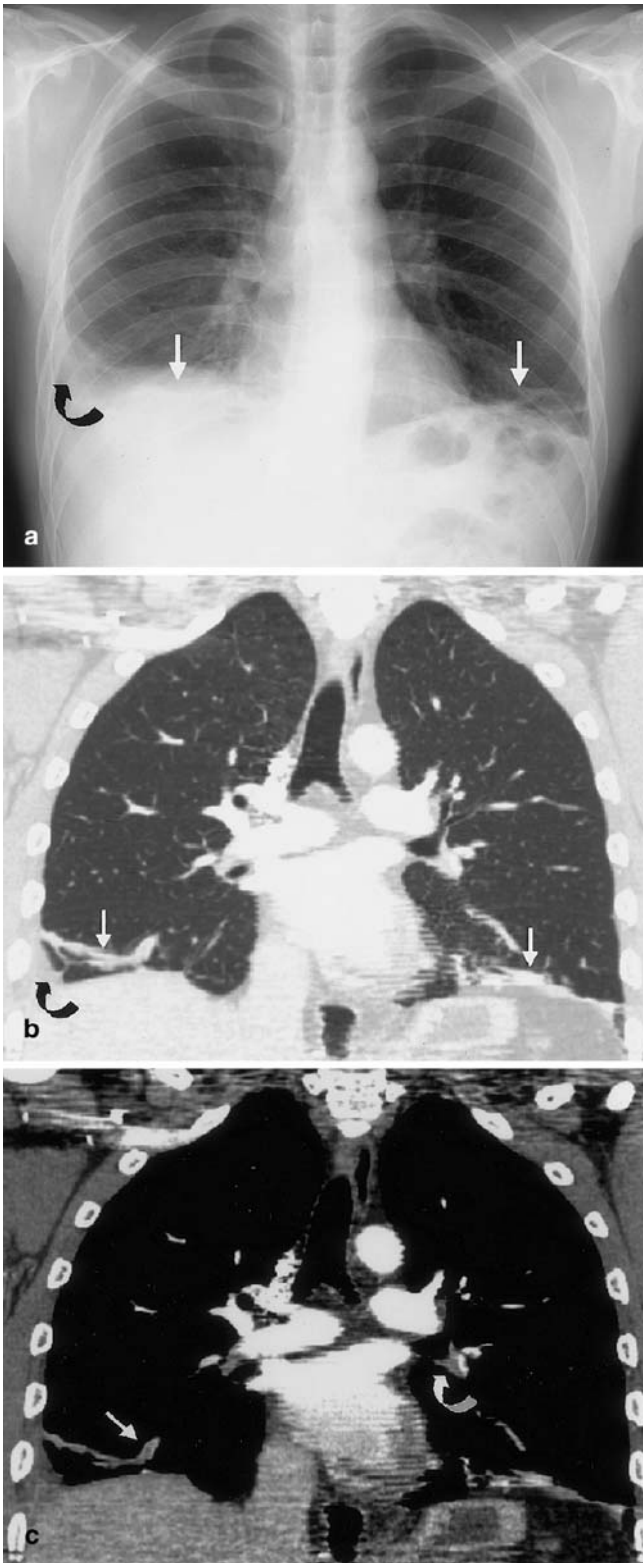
A 36-year-old man with vague thoracic pain and mild dyspnea. Treatment with antibiotics was unsuccessful. a Frontal chest X-ray reveals linear densities in both lower lobes. The radiological appearance was consistent with atelectasis (*straight arrows*). b
